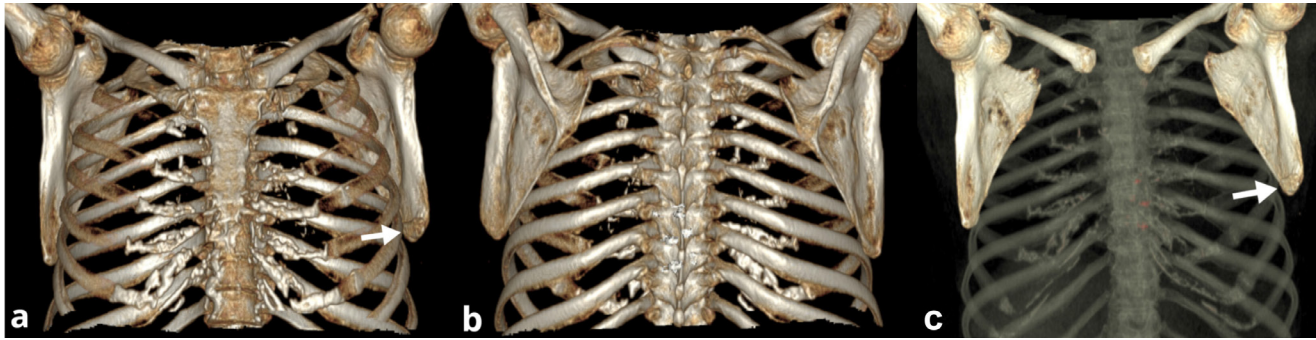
3D reconstructions of thorax CT images. a. Anterior view showing elevated left scapula due to Sprengel deformity with inferior angle ossicle (arrow). b. Posterior view showing elevated left scapula. c. In the anterior view with the transparent ribs, elevation in the left scapula and the accessory scapular ossicle (arrow) is clearly observed.
